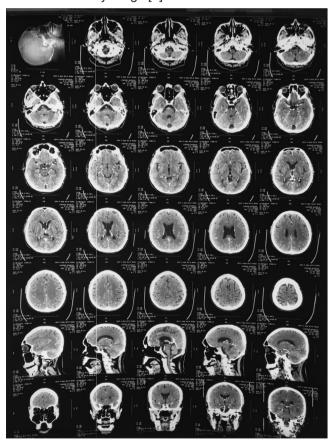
CT scan of the head with contrast of the patient, the conclusions were as follows: No bleeding, intracerebral SOL, or other intracranial abnormalities were seen
